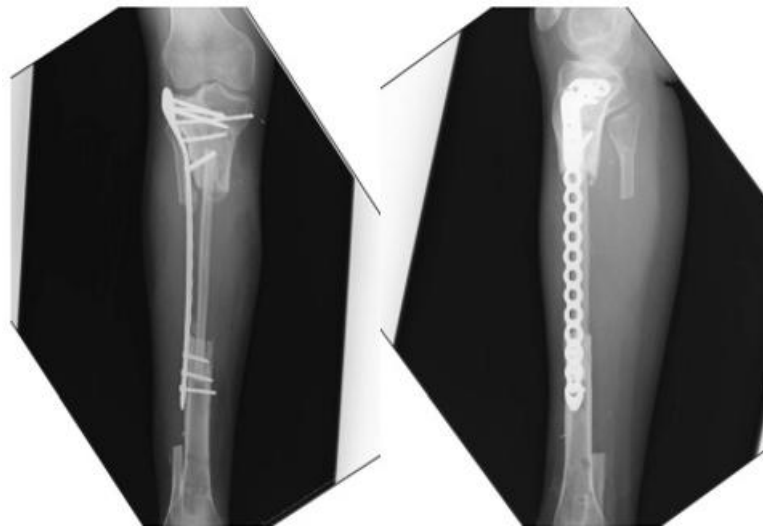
Clinical and radiographic appearance at the start of treatment
